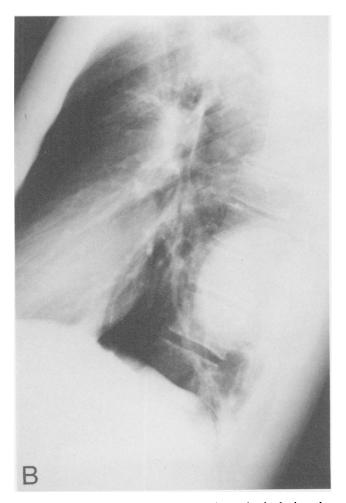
The lateral chest roentgenogram shows clearly the intrathoracic extent of the well-circumscribed tumor.
